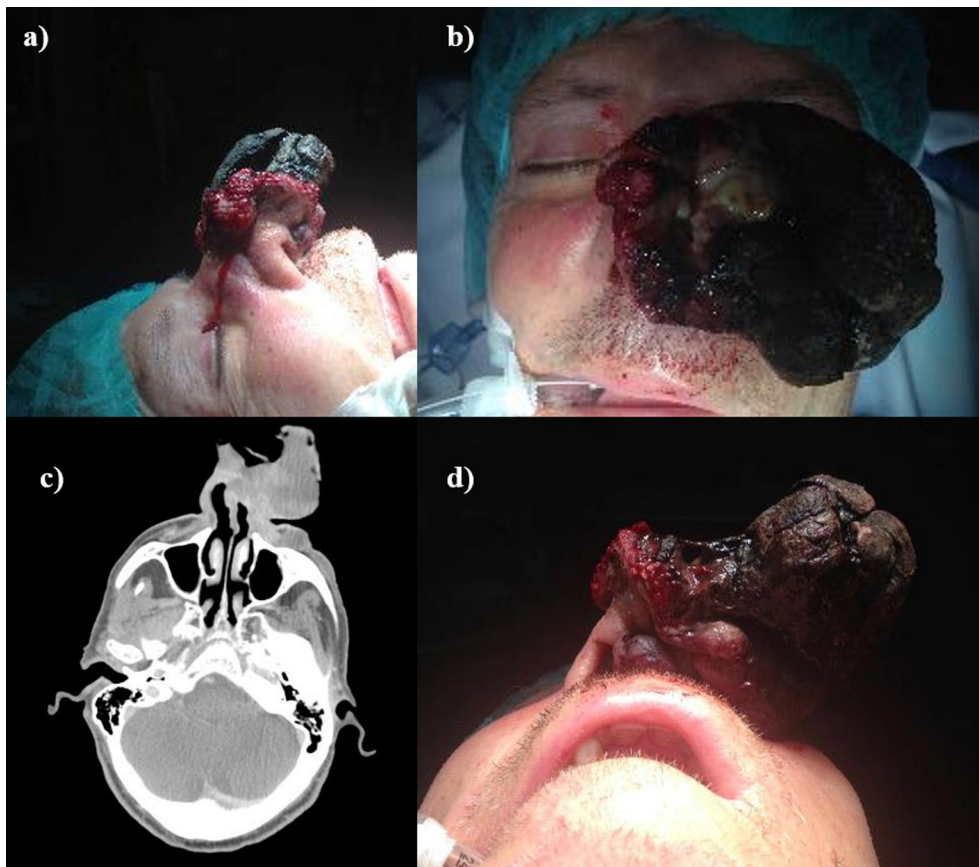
Patient with Large high-grade leiomyosarcoma (a, b, d), CT scan: the tumour involves the nose and the left nasolabial fold (c).
